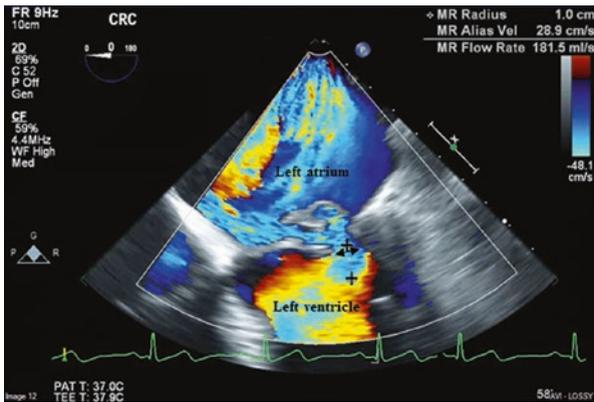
Color flow Doppler imaging of mitral valve regurgitation from the transesophageal echocardiographic Four-chamber mid-esophageal view with zoom-in on the mitral valve. Vena contracta (black double arrow) and proximal isovelocity surface area radius (the distance between the “+” signs) are shown
